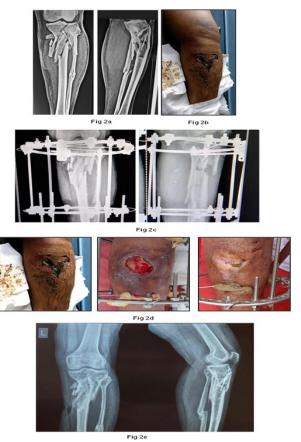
50-year-old male, Road Traffic Accident a) Radiographs showing Schatzker type VI Intra articular Proximal tibia fracture; b) Bad skin condition with full thickness patchy skin necrosis; c) Post-Operative radiographs after Ilizarov ring fixation; d) Gradual wound healing without need for extra plastic surgery procedures; e) 6 months after ring removal radiograph showing well united fracture in good alignment.
